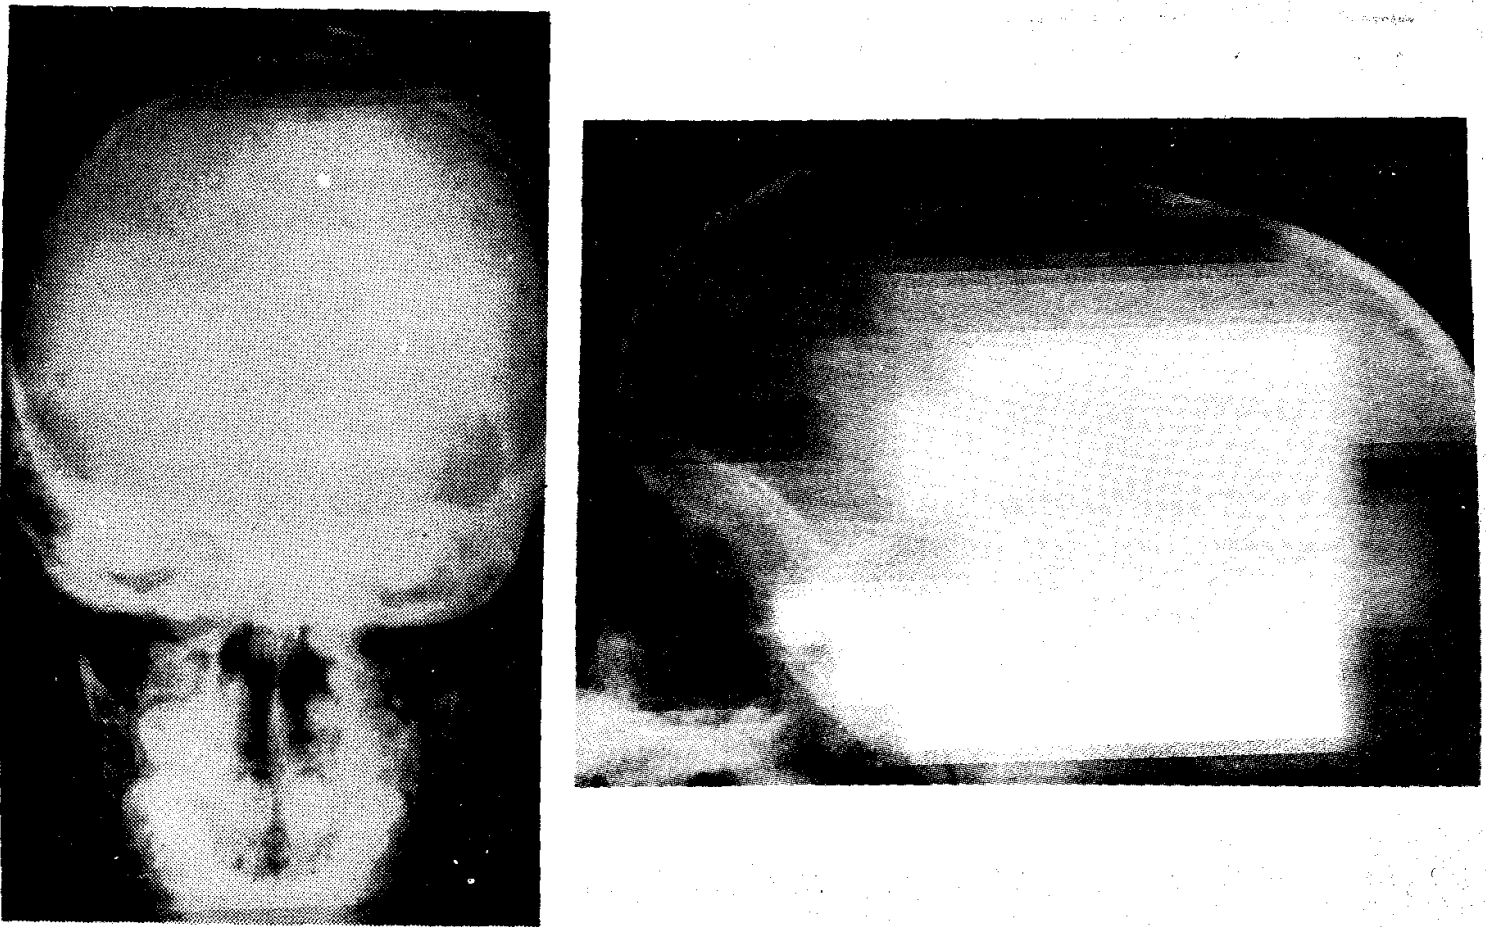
AP (a) and Lateral (b) radiographs of skull showing irregular, multiple, coalescing osteolytic lesion in the left parietal bone. Margins are not sharply demarcated and there is no sclerosis.
